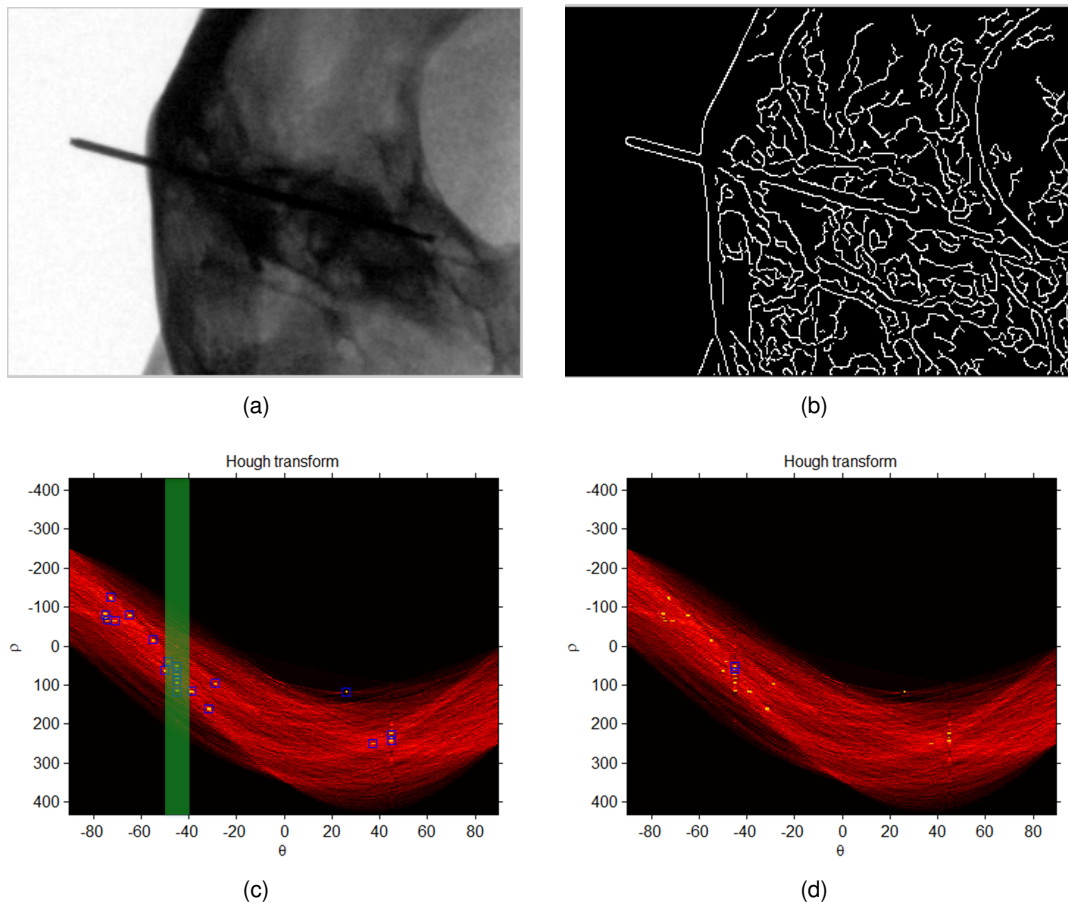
An example showing how the boundary lines of the drill bit are identified. First the input image (a) is processed with Canny-edge detector (b), then the Hough transform is applied to it and the peaks are identified (c). Finally, the boundary lines are selected based on the expected orientation and diameter of the projection of the drill bit on the X-ray image (d).
